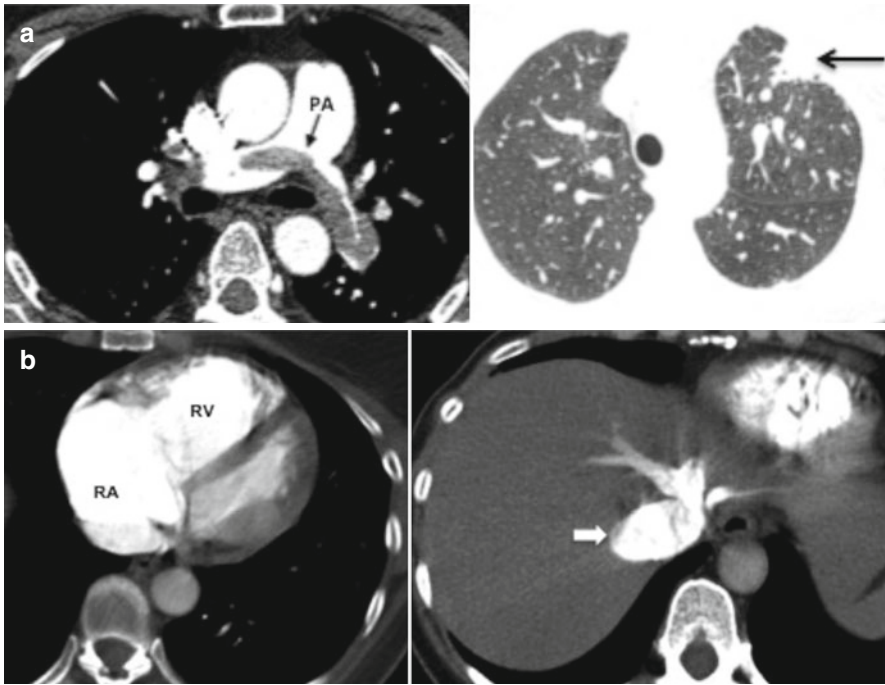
(a, b) Selected CT images from a contrast enhanced angiographic examination of a 40-year old female patient who presented with shock secondary to extensive pulmonary emboli. (a) *Left panel*, mediastinal window. The pulmonary artery (PA) is dilated with a saddle embolus (*black arrow*). *Right panel*, lung window. There is a peripheral wedge shaped infarct in left upper lobe (*black arrow*). (b) There is marked dilatation of right atrium (RA) and right ventricle (RV) and reflux of contrast medium in to the inferior vena cava and hepatic veins (*black arrow*)
